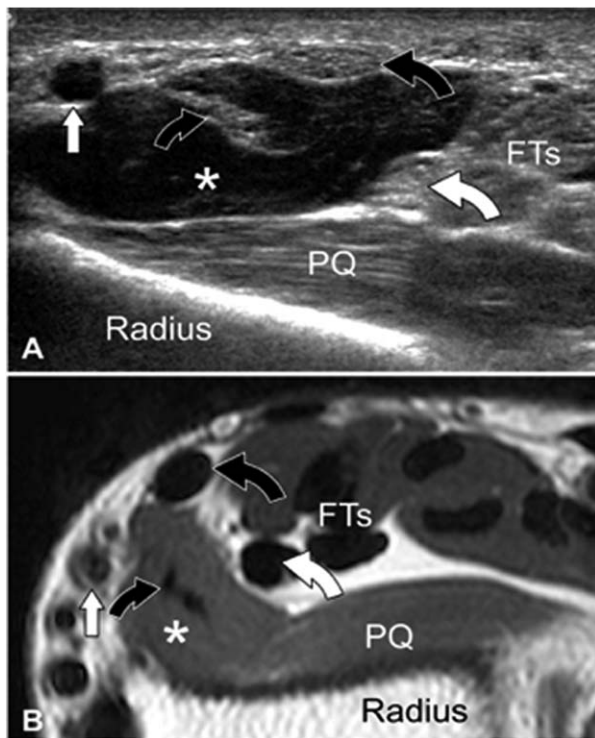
Transverse US (A) and MRI (B) appearance. Images show the relationships of the flexor carpi radialis brevis muscle (asterisks) and tendon (small curved black arrows) with the pronator quadratus muscle (PQ), the flexor carpi radialis tendon (large curved black arrows), the radial artery (white arrows), and the flexor pollicis longus tendon (curved white arrows). FTs indicates flexor tendon.
